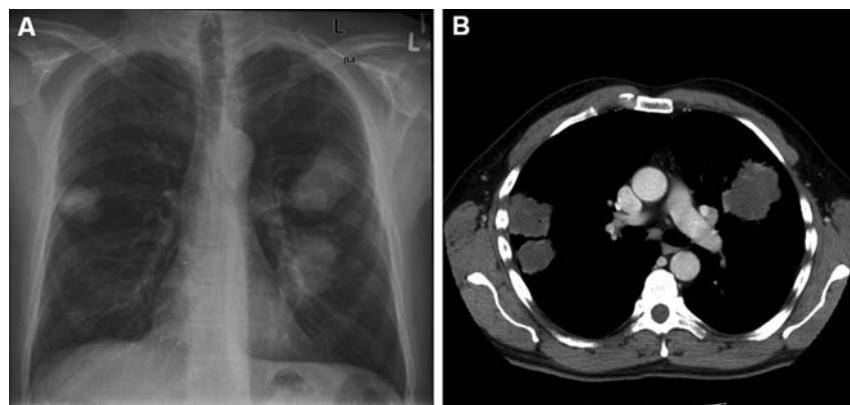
A) Chest radiograph and B) computed tomographic scan of the patient showing 3 nodular *Cryptococcus gattii* infiltrates near pleura.
